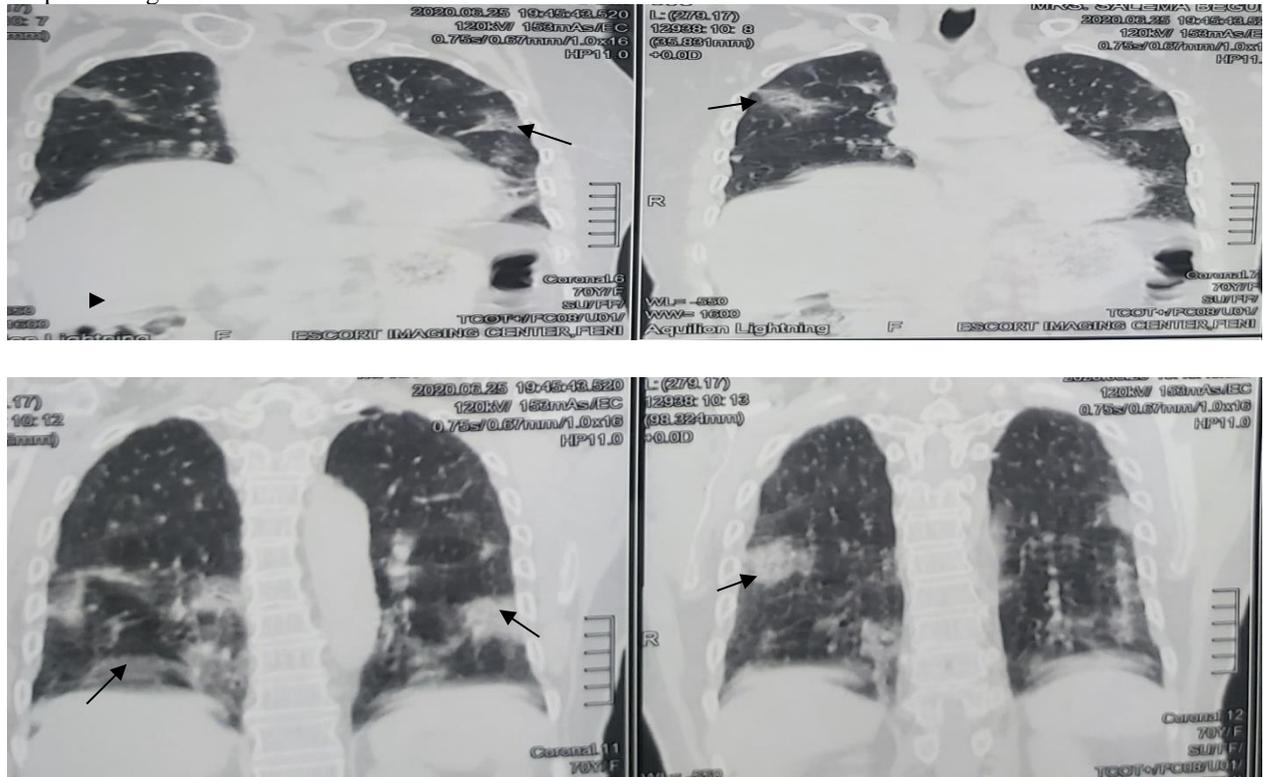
(A and B). HR CT of chest (Axonal views) showing (black arrows) multifocal ground glass density and early sub segmental consolidations are seen at multiple segments of both lungs predominantly distributed at peripheral, peri bronchoalveolar and subpleural regions. The ground glass density involved approximately 30% of lung volume.
